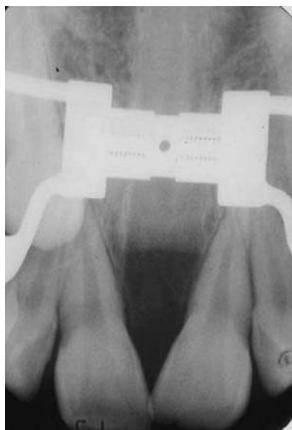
Note intersegmentary bone formed in the maxillary midline after surgically assisted rapid palatal expansion on this occlusal radiograph. The device has been left on after the distraction phase to serve as a retainer during the consolidation phase.
